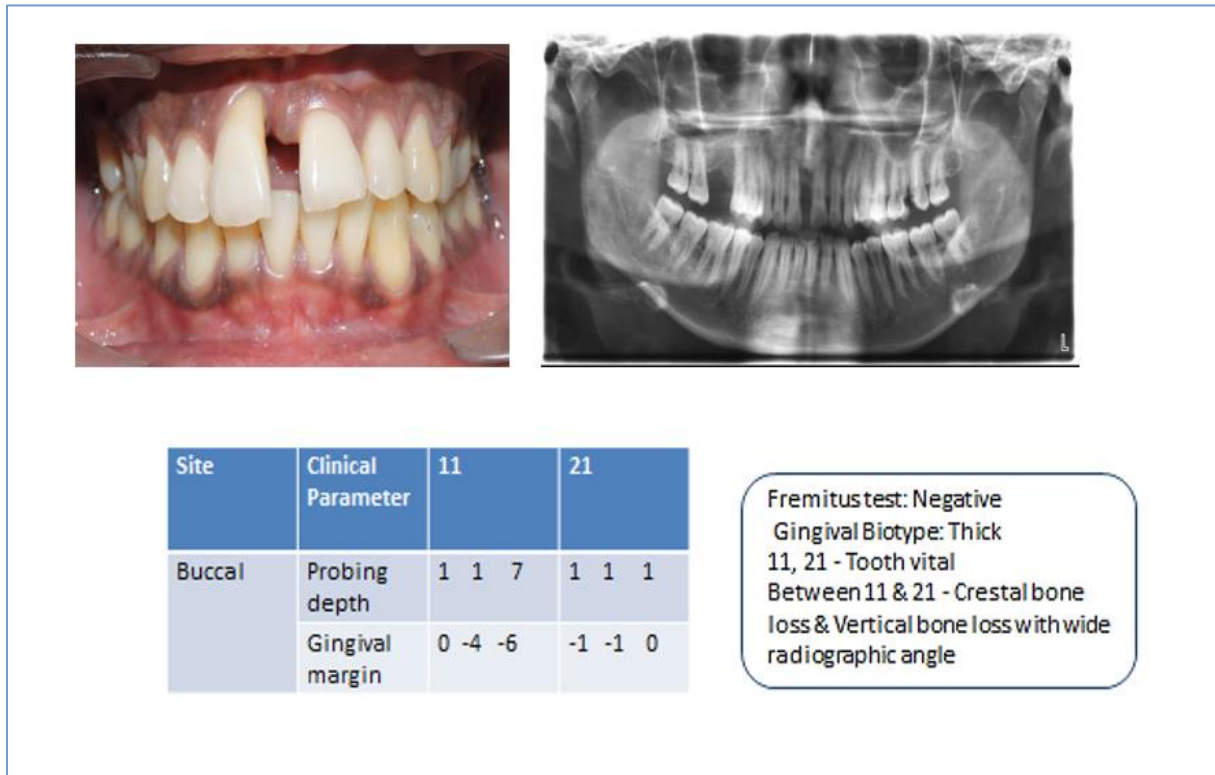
Case 1 – Clinical & Radiographic Photographs
